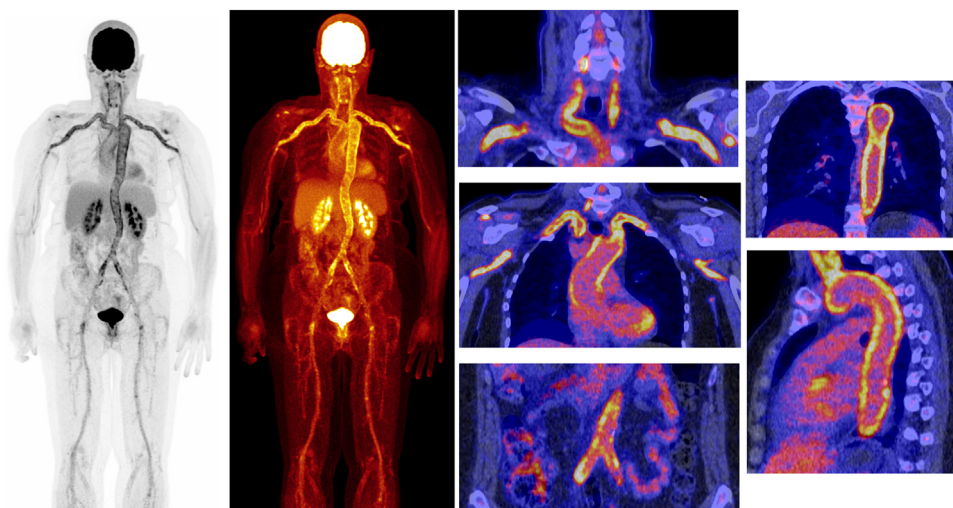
FDG TBPET in GCA. FDG LAFOV QUADRA PET/CT of GCA with vasculitis activity of the thoracic and abdominal aorta, carotid, subclavian, axillary, and iliac arteries. On the left MIP in colour, in the middle and on the right fused FDG PET and low dose CT images.
